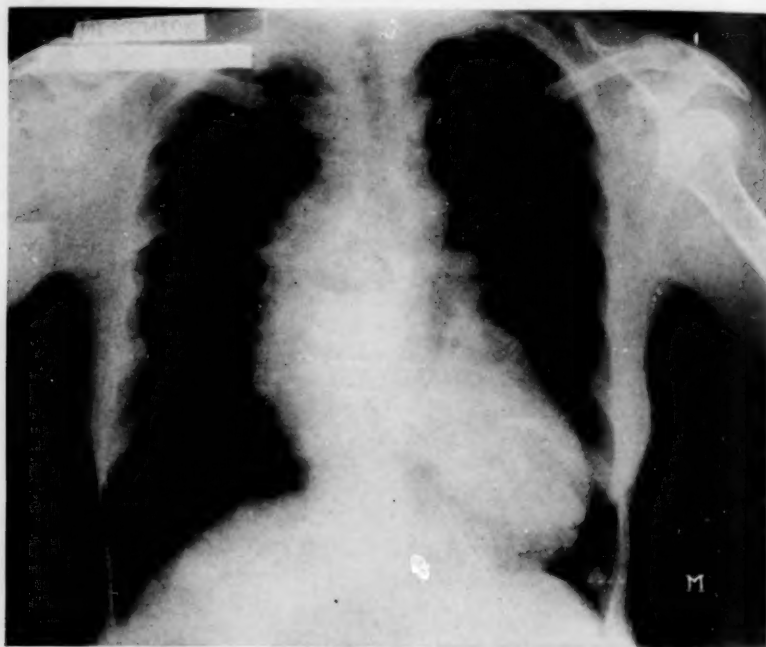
X-ray taken before operation. The large mediastinal tumor has crowded the heart to the left. The supposed metastasis in the lung is indicated by "M."
